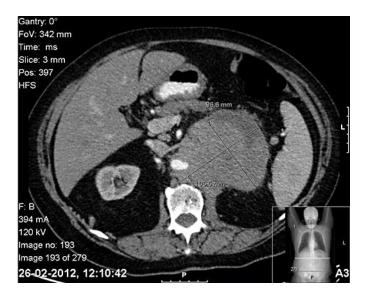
CT scan performed in February 2012, revealed a retroperitoneal mass.
